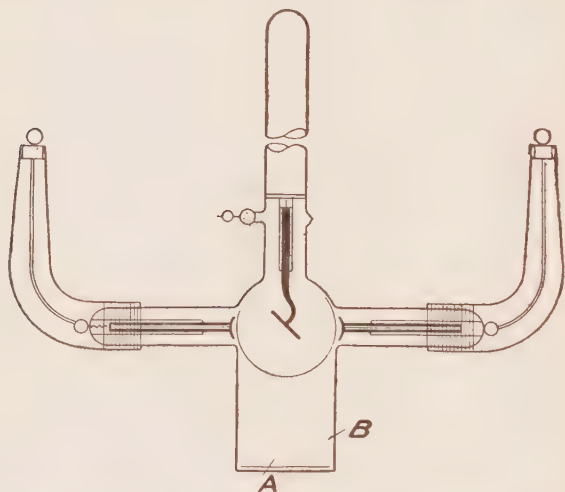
Represents a modification of the Piffard tube. It is known as the Cornell treatment tube. The main chamber "B" is made of lead glass. "A" is a soda glass window at the end which allows the X-rays to pass through it. This tube is very small and as used by Dr. Albert Geyser, the soda glass window "A" is to be kept in permanent contact with the part to be treated.
